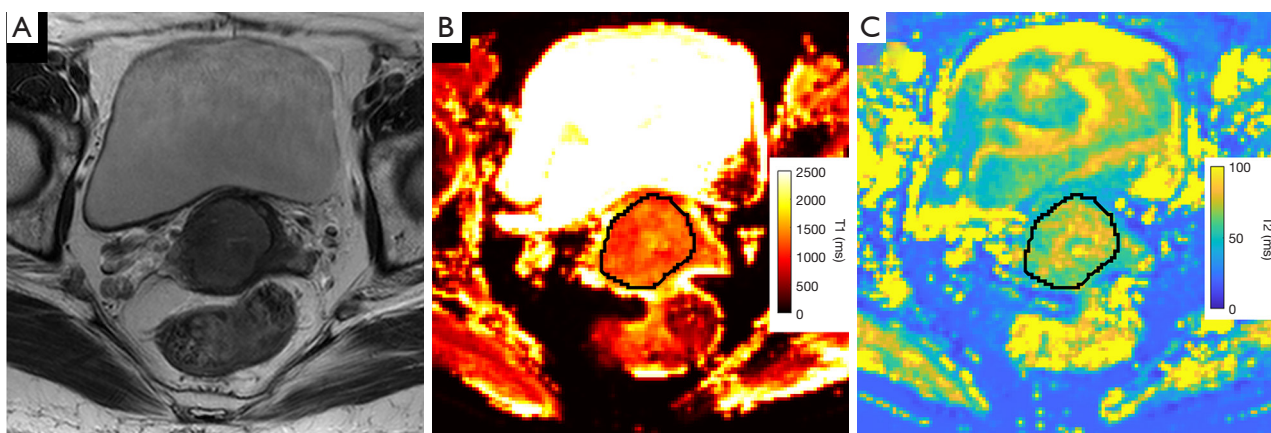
A 64-year-old woman with squamous cell carcinoma, tumor grade G3 and FIGO stage IIB. (A) Axial T2-weighted image, (B) T1 map and (C) T2 map. Representative VOI of the CC on T1 and T2 maps were also shown (VOIs appear as black circles). FIGO, International Federation of Gynecology and Obstetrics; VOI, volume of interest; CC, cervical carcinoma.
